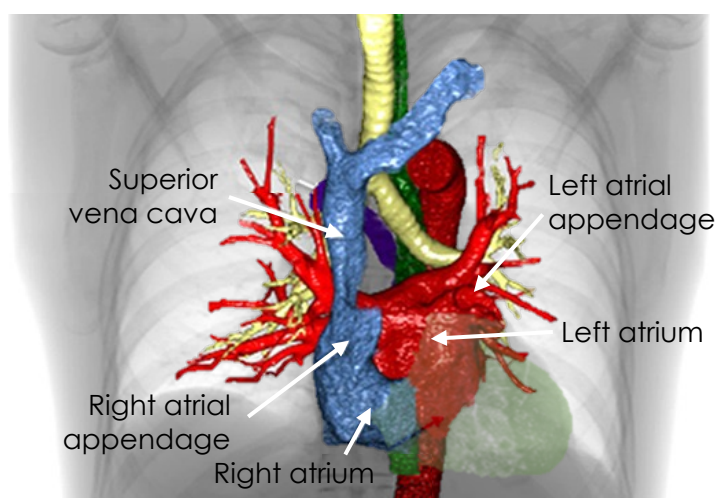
Location of the atria within the thoracic cavity. Frontal chest radiography showing structures segmented from computed tomography imaging. The ventricles appear attenuated in green. Adapted from [131] with permission from the publisher.
